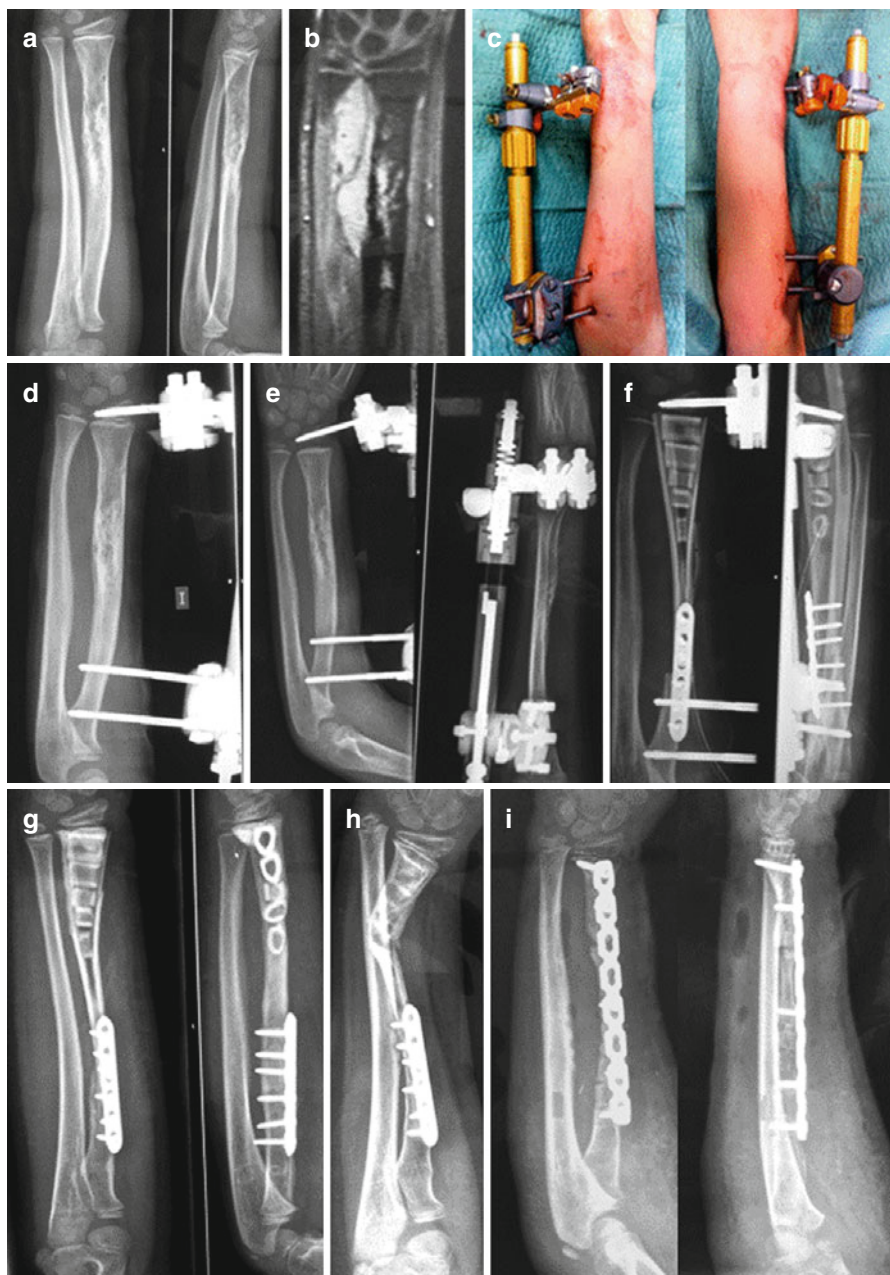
(a, b) X-ray and MRI of a Ewing's sarcoma in the distal left radius of a 6-year-old girl. (c-e) Physelal distraction before excision. (f) After reconstruction with a contralateral fibular autograft. (g) Union of the autograft with active growth plate 6 months after surgery. (h, i) Fracture of the graft and treatment of this fracture
